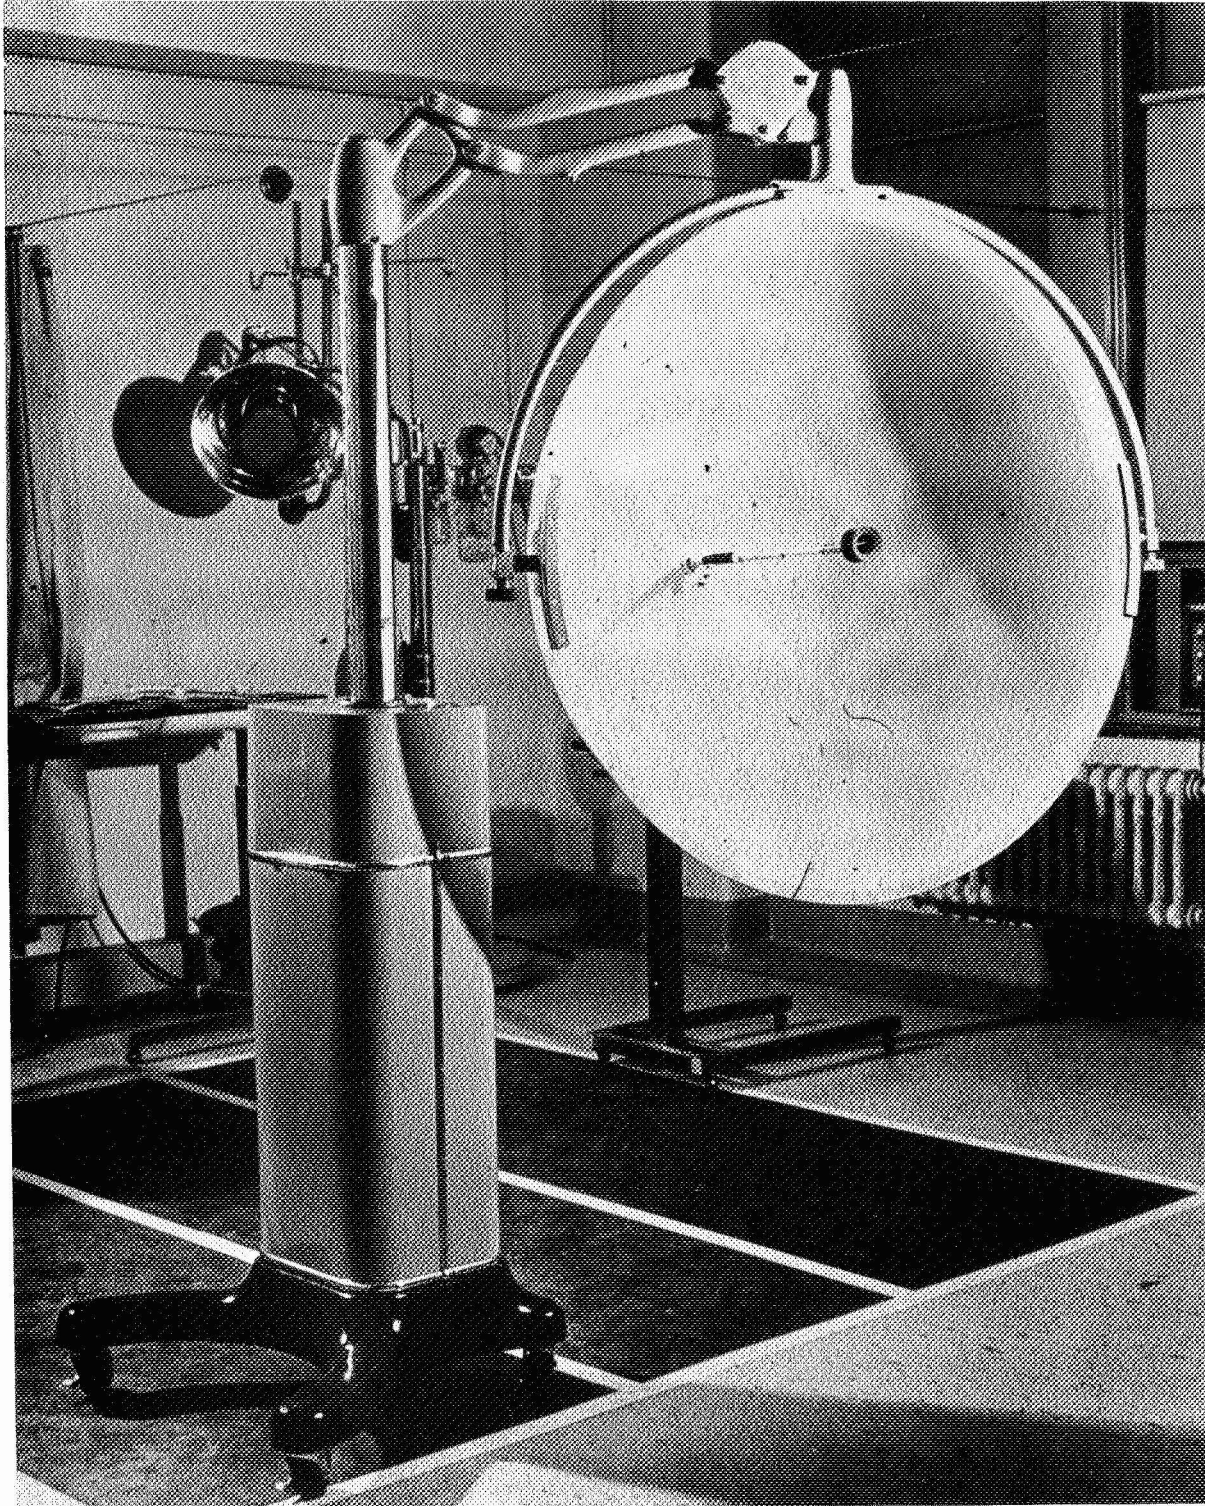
A 42-inch methyl methacrylate hemisphere mounted on an x-ray stand serves as a bowl perimeter.
